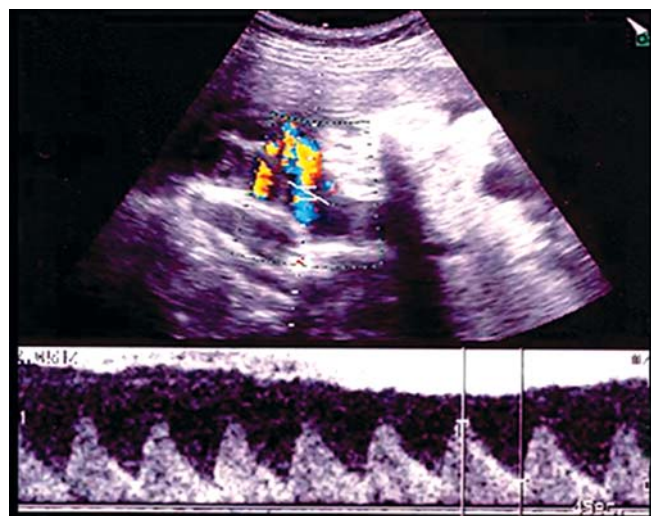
Normal Doppler waveforms from the umbilical artery
